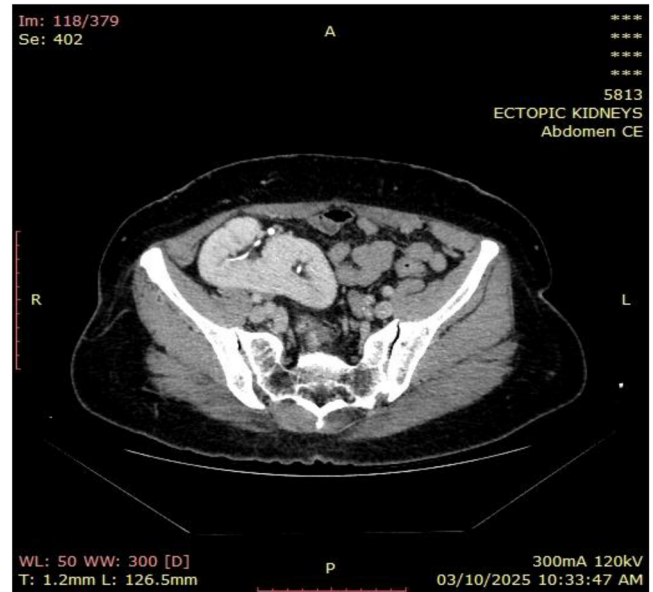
Contrast-enhanced axial computed tomography (CT) image of the abdomen (nephrogenic phase) demonstrating crossed fused kidneys in the right iliac region, each with a distinct ureter.
